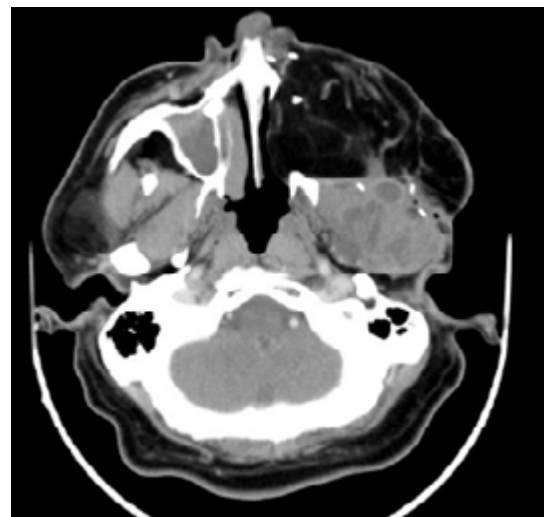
Computed tomography of paranasal sinuses with evidence of heterogeneous and hypotensive mass in the left masticator space of lobed contours with dimensions of 36.7x53.6x42.7mm.
